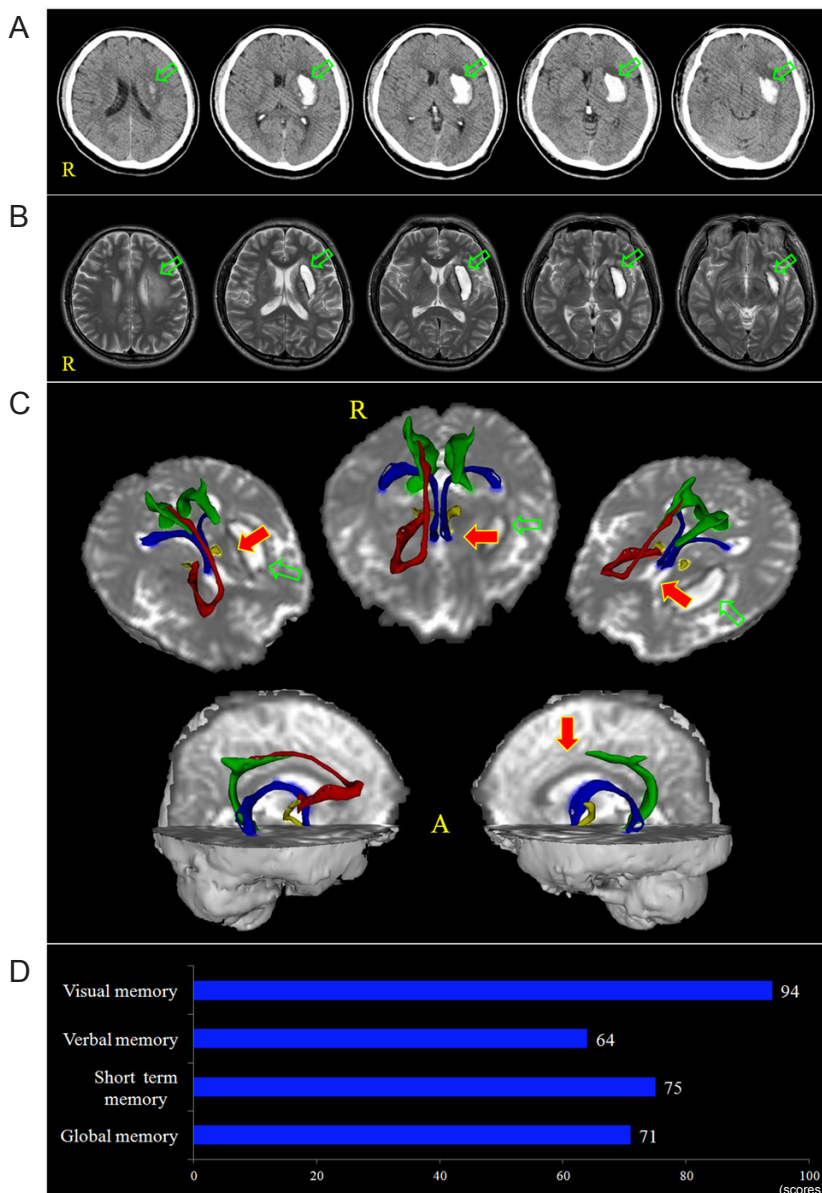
Brain CT, T2-weighted MR images, and diffusion tensor tractography (DTT) images of a 55-year-old male patient with a putaminal hemorrhage in the left hemisphere exhibiting cognitive dysfunction.
